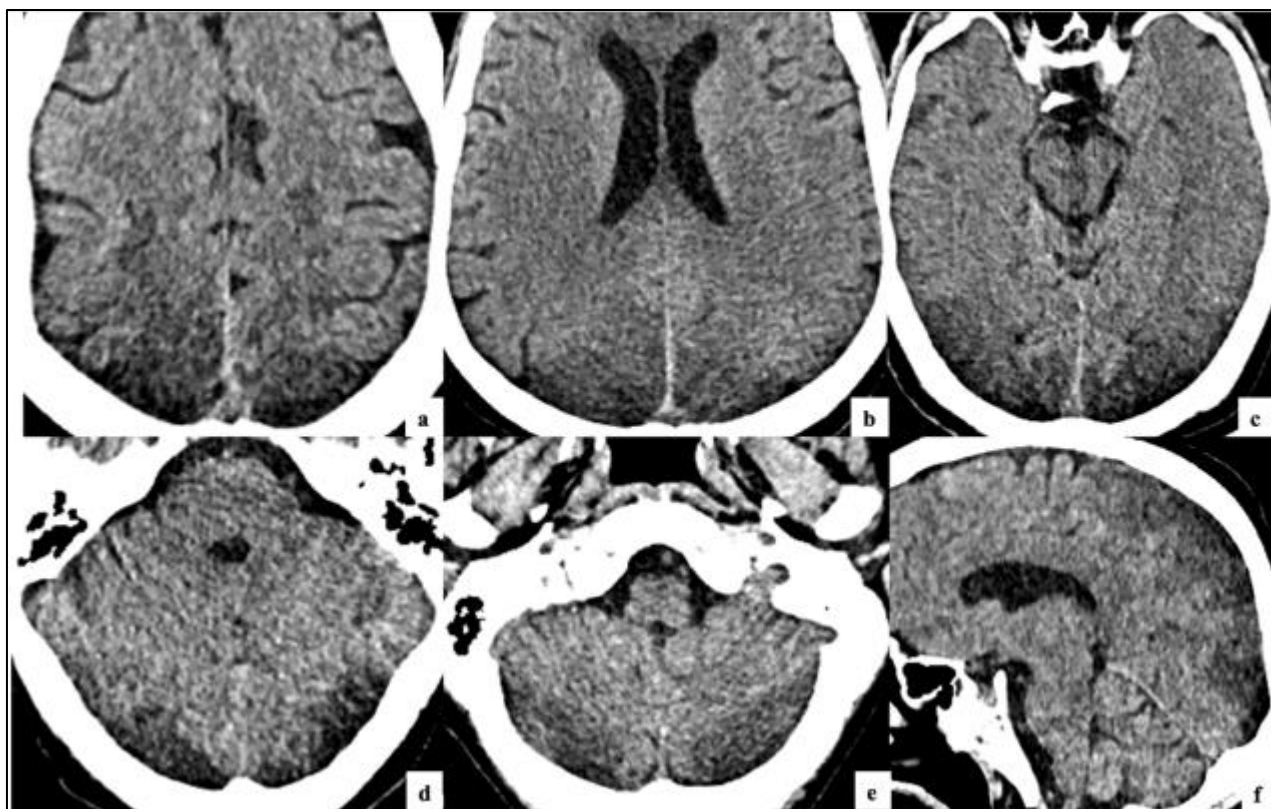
(a – f). Axial and sagittal non-contrast CT scan images : Symmetrical abundant vasogenic edema involving the posterior occipitoparietal regions and the posterior cerebellum, without obvious hemorrhage or calcifications
